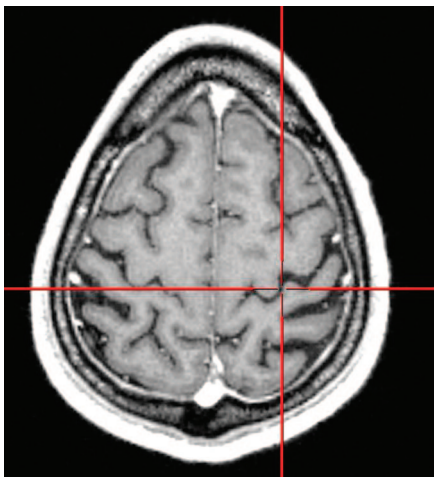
T1-weighted axial MRI scan showing the central sulcus.
